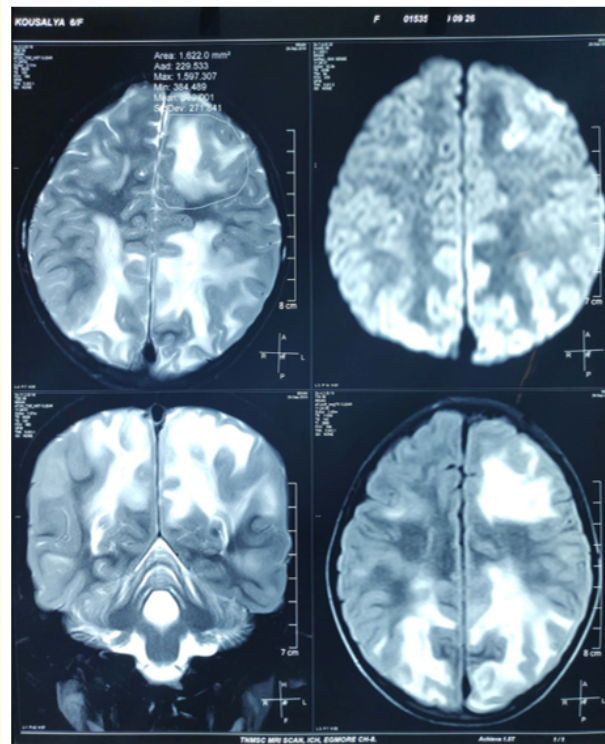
MRI of brain T2 sequence showing hyperintense areas involving fronto-parieto-occipital region suggestive of extensive bilateral white matter edema.
